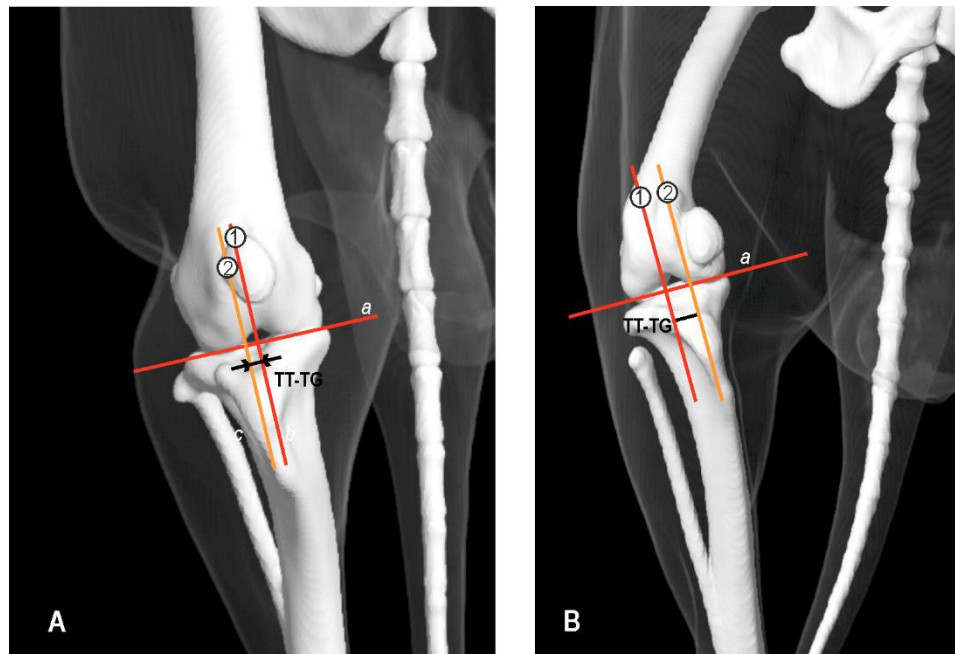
Measurement of the TT-TG distance on 3D reconstructed CT image of a healthy stifle joint (A) and a stifle with grade II medial patellar luxation (B) using the red reference line and the two perpendiculars from trochlear groove bottom (1) and tibial tubercle (2).
